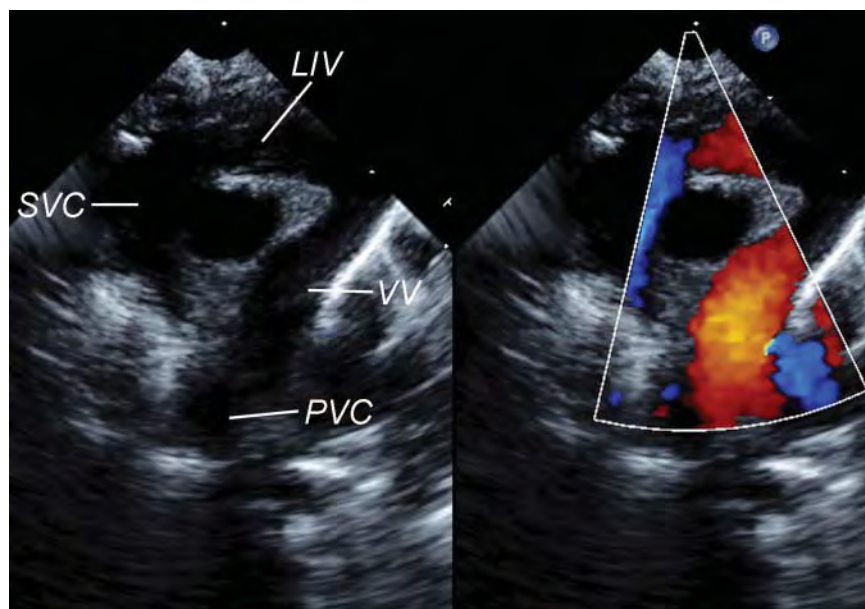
Parasternal short axis echocardiogram view with color Doppler flow mapping in this patient with supracardiac TAPVC to the left innominate vein (LIV) shows the pulmonary venous confluence (PVC) which drains via the vertical vein (VV) toward the leftward aspect of the innominate vein. SVC, superior vena cava.
